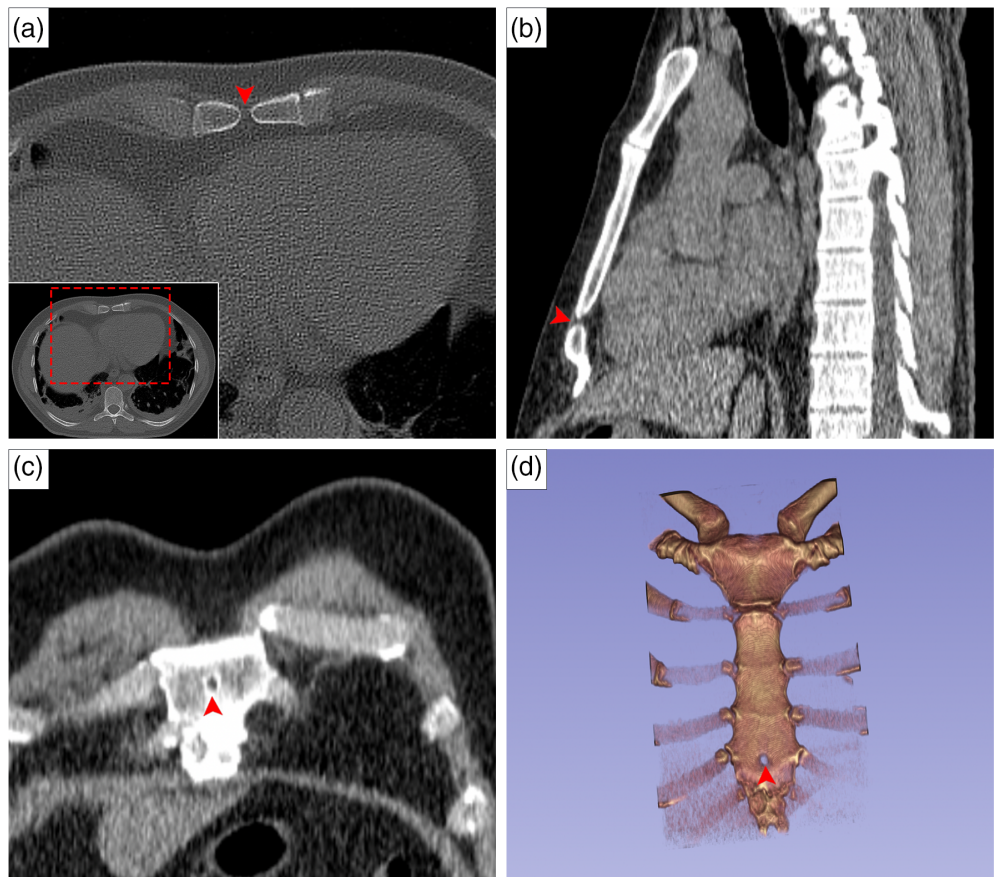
Axial (A), sagittal (B), coronal (C) CT images, and 3D reconstruction in anteroposterior view (D) of the sternal foramen (red arrowheads). An interactive 3D file is available in the supporting information
